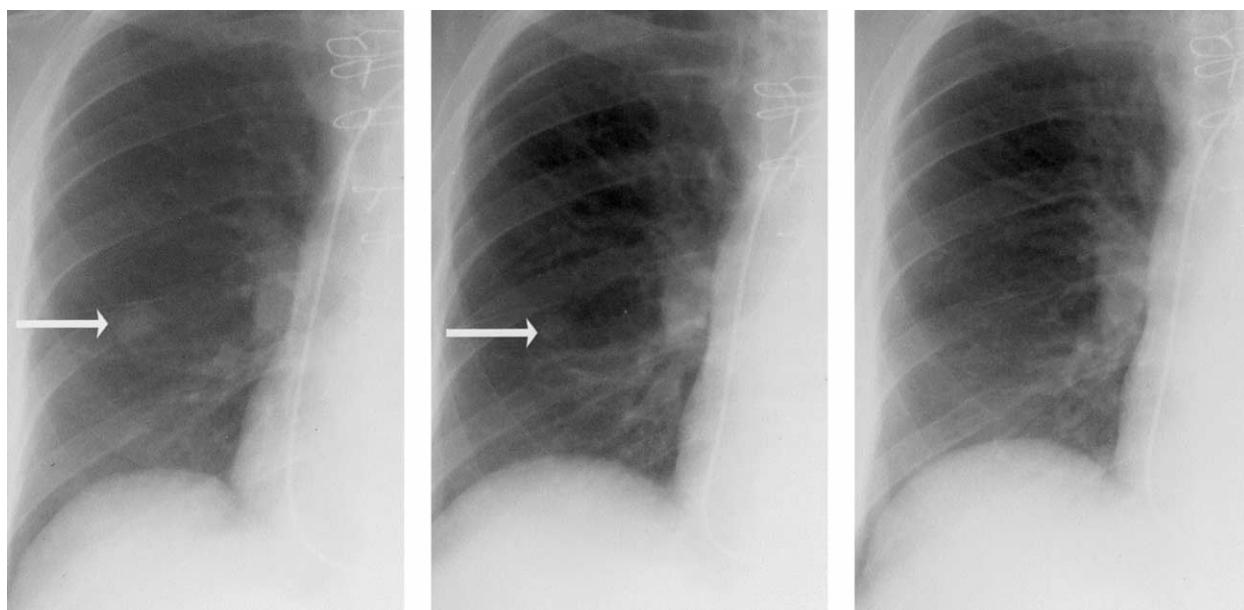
Evolution of treated invasive pulmonary aspergillosis in a 56-year-old cardiac transplant recipient. A, Radiograph obtained at the time of initial detection, showing a 1.5-cm nodule (arrow) in the right middle lung zone; B, Radiograph obtained 8 days later, showing an interval decrease in the size of the nodule (arrow); C, Radiograph obtained 59 days after the time of initial detection, showing resolution of the nodule.
